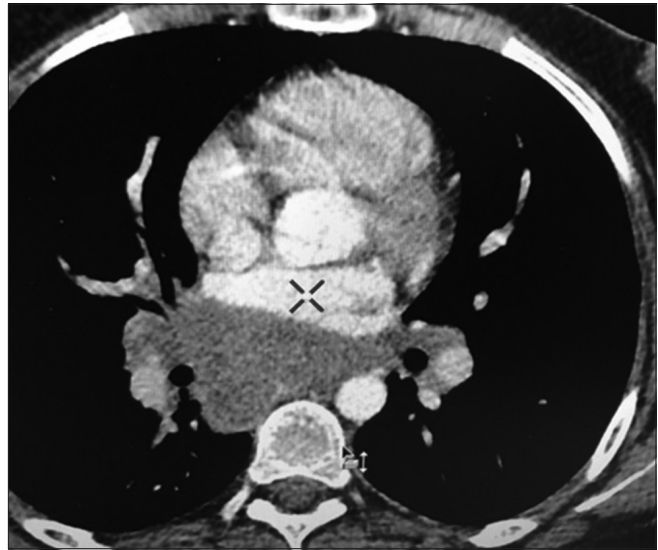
High-resolution CT chest showing mediastinal mass
